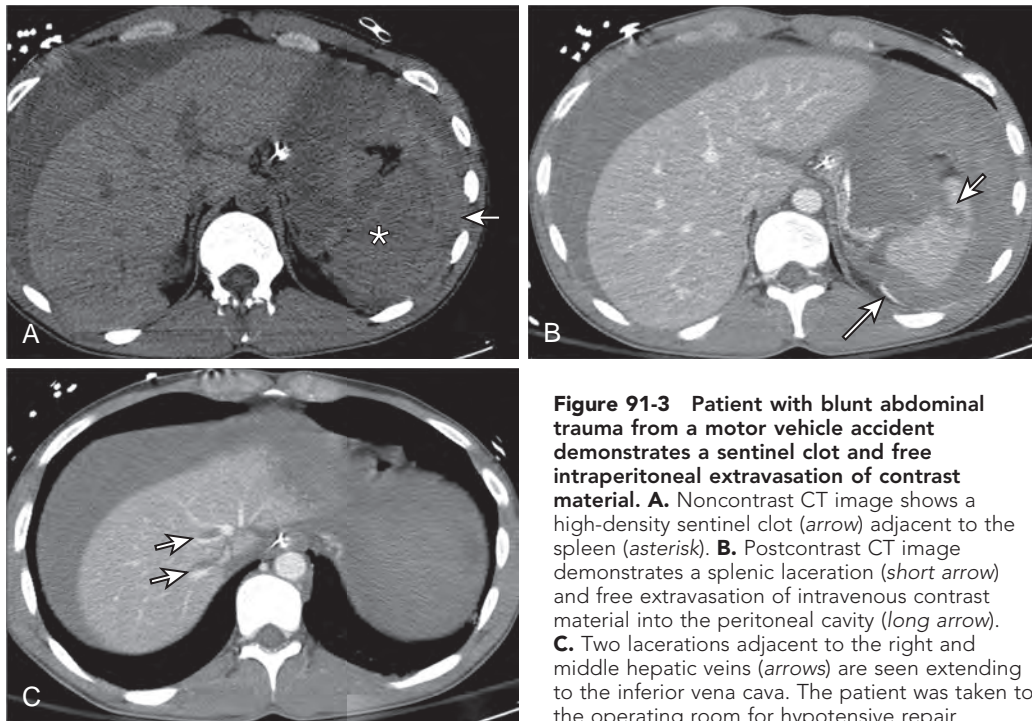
Patient with blunt abdominal trauma from a motor vehicle accident demonstrates a sentinel clot and free intraperitoneal extravasation of contrast material. A. Noncontrast CT image shows a high-density sentinel clot (arrow) adjacent to the spleen (asterisk). B. Postcontrast CT image demonstrates a splenic laceration (short arrow) and free extravasation of intravenous contrast material into the peritoneal cavity (long arrow). C. Two lacerations adjacent to the right and middle hepatic veins (arrows) are seen extending to the inferior vena cava. The patient was taken to the operating room for hypotensive repair.
